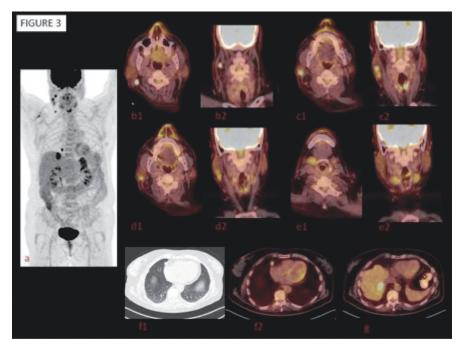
FDG PET scan in a patient presenting with asthenia and cervical lymph nodes. Whole-body FDG PET scan (a) shows hypermetabolic cervical lymph nodes in axial (b1, c1 d1, and e1) and coronal (b2, c2, d2 and e2) images. Moreover, pulmonary paracardiac lymph nodes (f1 and f2) nodes hypermetabolic hepatic (g) and were also seen. A diagnosis of sarcoidosis was confirmed after a lymph node and hepatic biopsy disclosing non-caseating granulomas.
